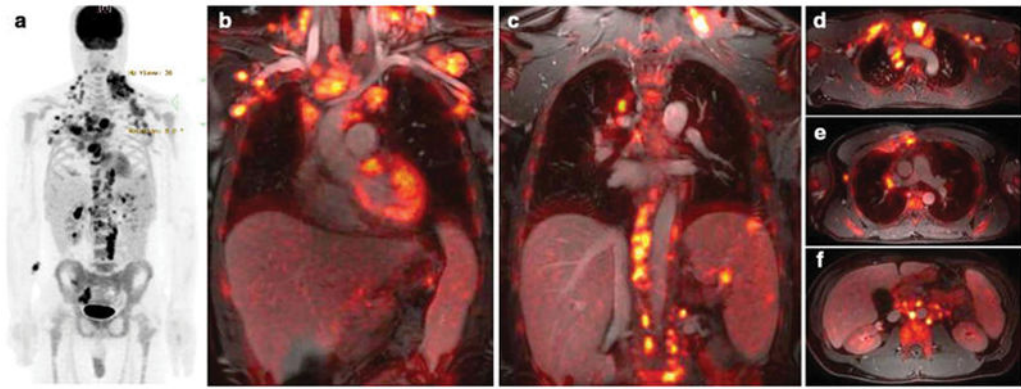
Whole Body ^{18}F -FDG PET/MR of a patient with Hodgkin Lymphoma
